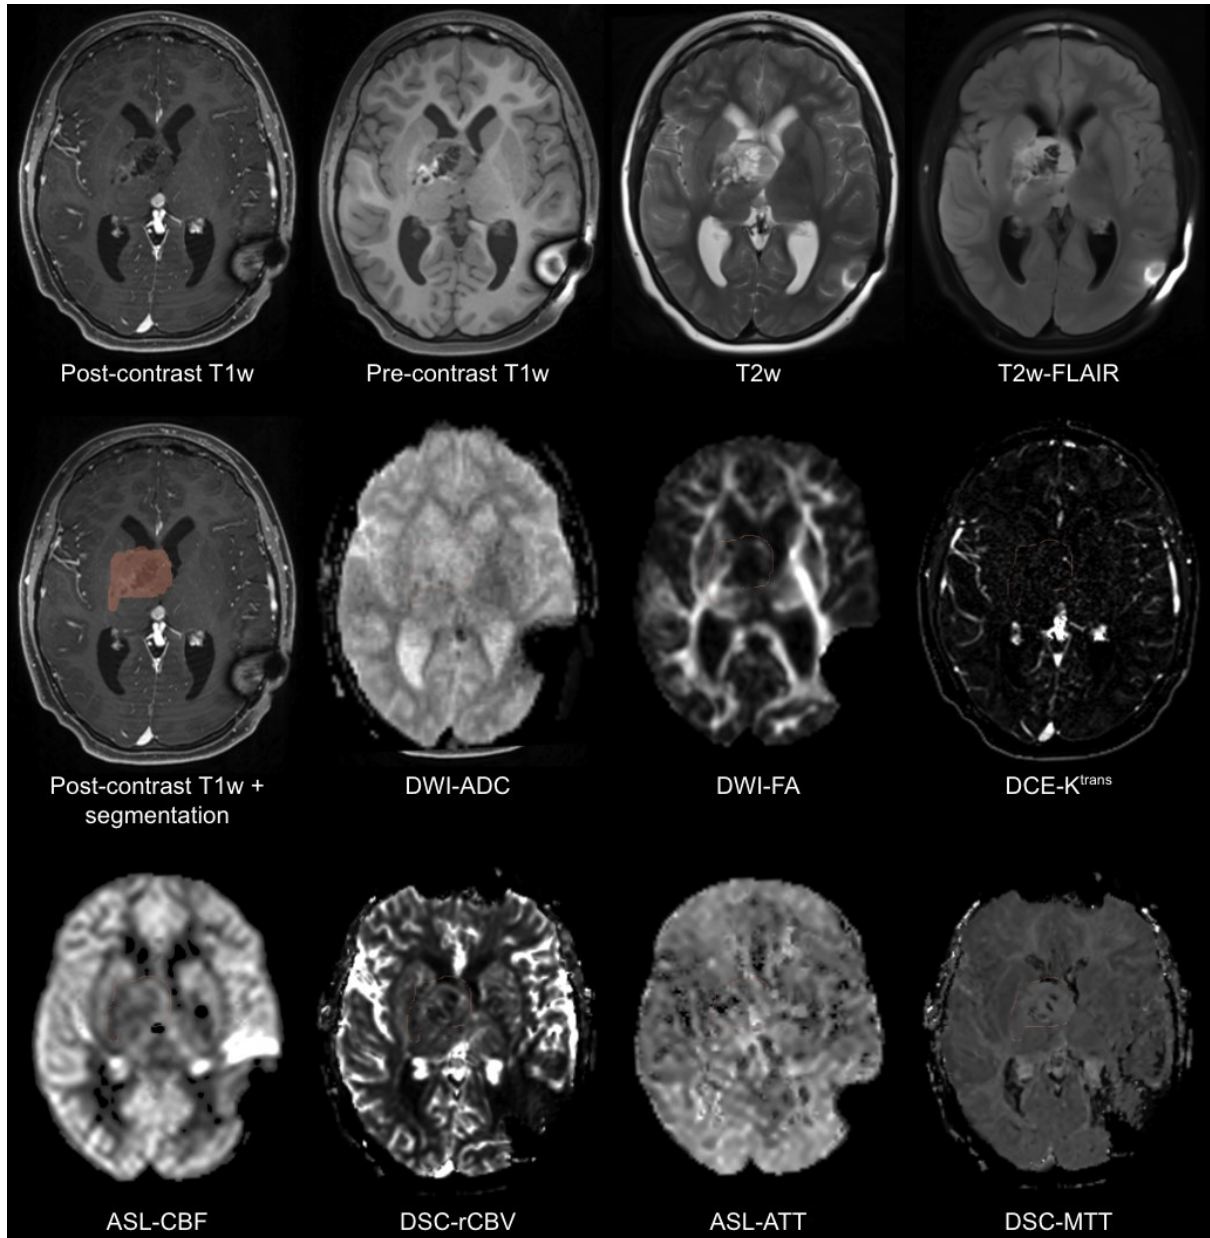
Structural (pre- and post-contrast T1w, T2w, T2w FLAIR, and DWI) and perfusion (DCE, ASL, and DSC) pre-treatment scans of a pediatric patient with WHO MAPK-pathway altered diffuse LGG. ASL was acquired using a sequential multi-delay protocol. APT-CEST imaging was not performed due to the unavailability of the sequence on the scanner at the time of imaging.
